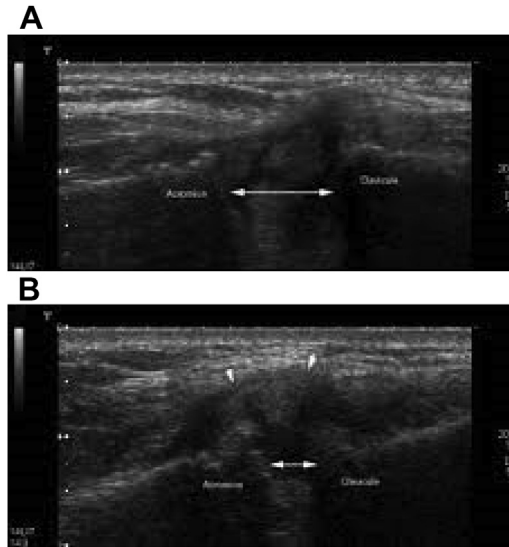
Picture taken from Peetrons and Bedard²⁴ demonstrating the ultrasound findings for an AC joint dislocation.
